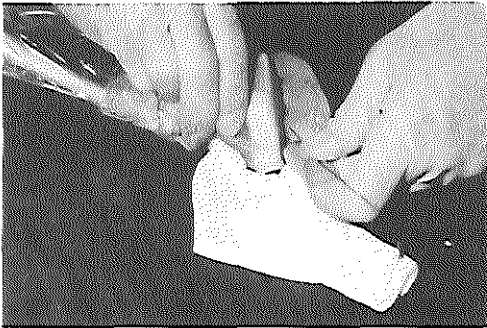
Ultrasound guided drainage of a neck abscess using the Seldinger technique. A 22 G Chiba needle, packed in a sterile bag, is used.
